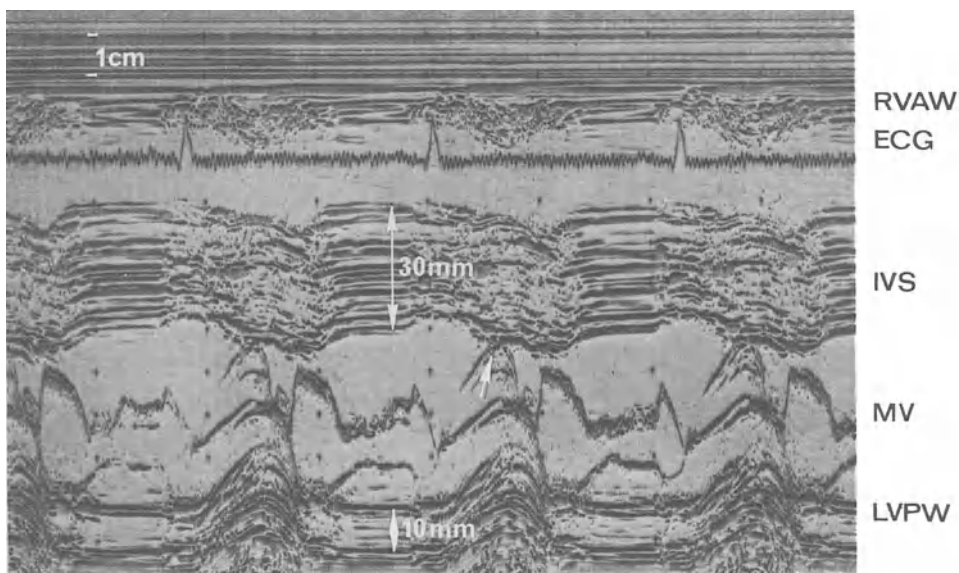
Echocardiogram of a patient with ASH (ratio of septum to left ventricular posterior wall 3.0) and outflow obstruction, which is indicated by the systolic anterior movement of both mitral valve leaflets. *RVAW*: right ventricular anterior wall, *IVS*: interventricular septum, *MV*: mitral valve, *LVPW*: left ventricular posterior wall
